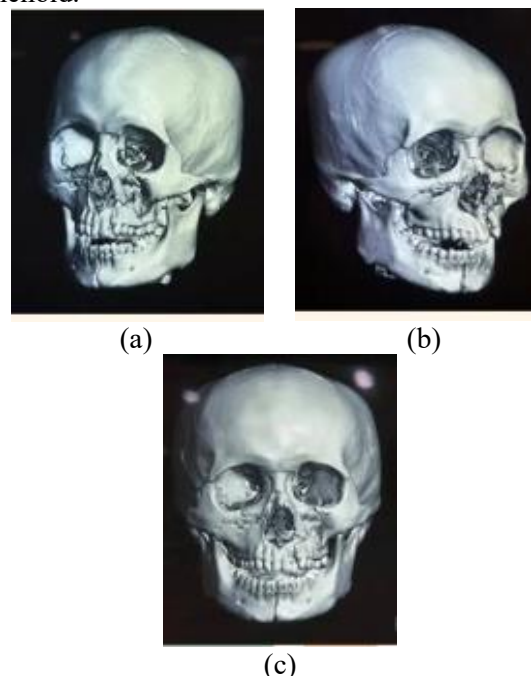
The patient's CT-Scan showed Le-Fort II fracture, nasal fracture and symphysis fracture. (a) Left lateral appearance; (b) Right lateral appearance; (c) Front view.
